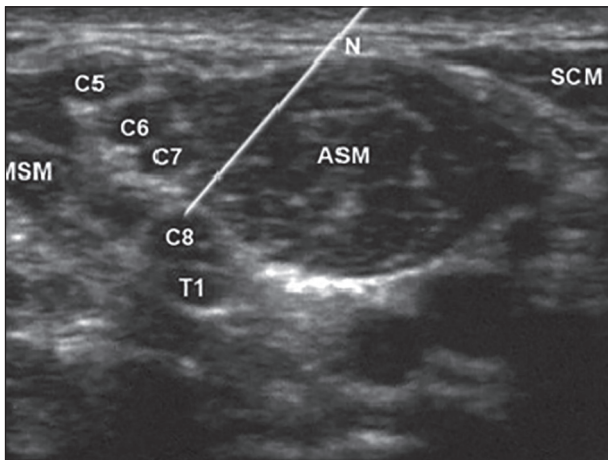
Showing ultrasonographic imaging of brachial plexus (ASM: Anterior scalene muscle, MSM: Medial scalene muscle, SCM: Sternocleidomastoid muscle)
